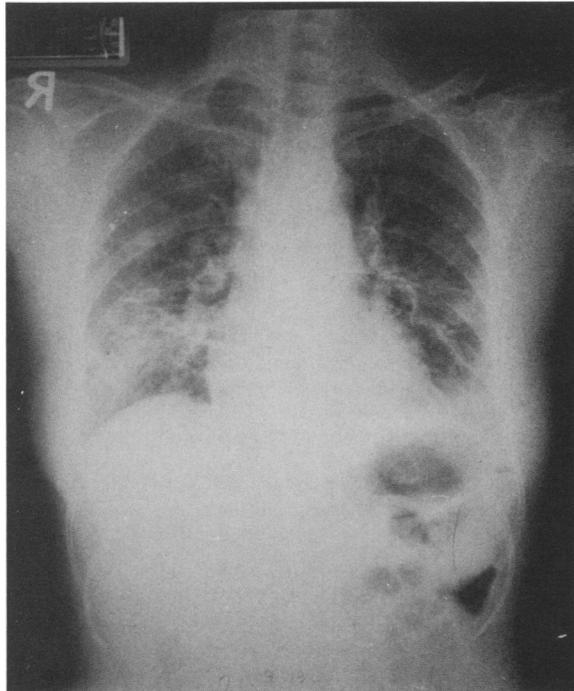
Chest X-ray on the day of admission showing bilateral pulmonary infiltrates, left pleural effusions, and fractures of left 4th and 5th ribs.
